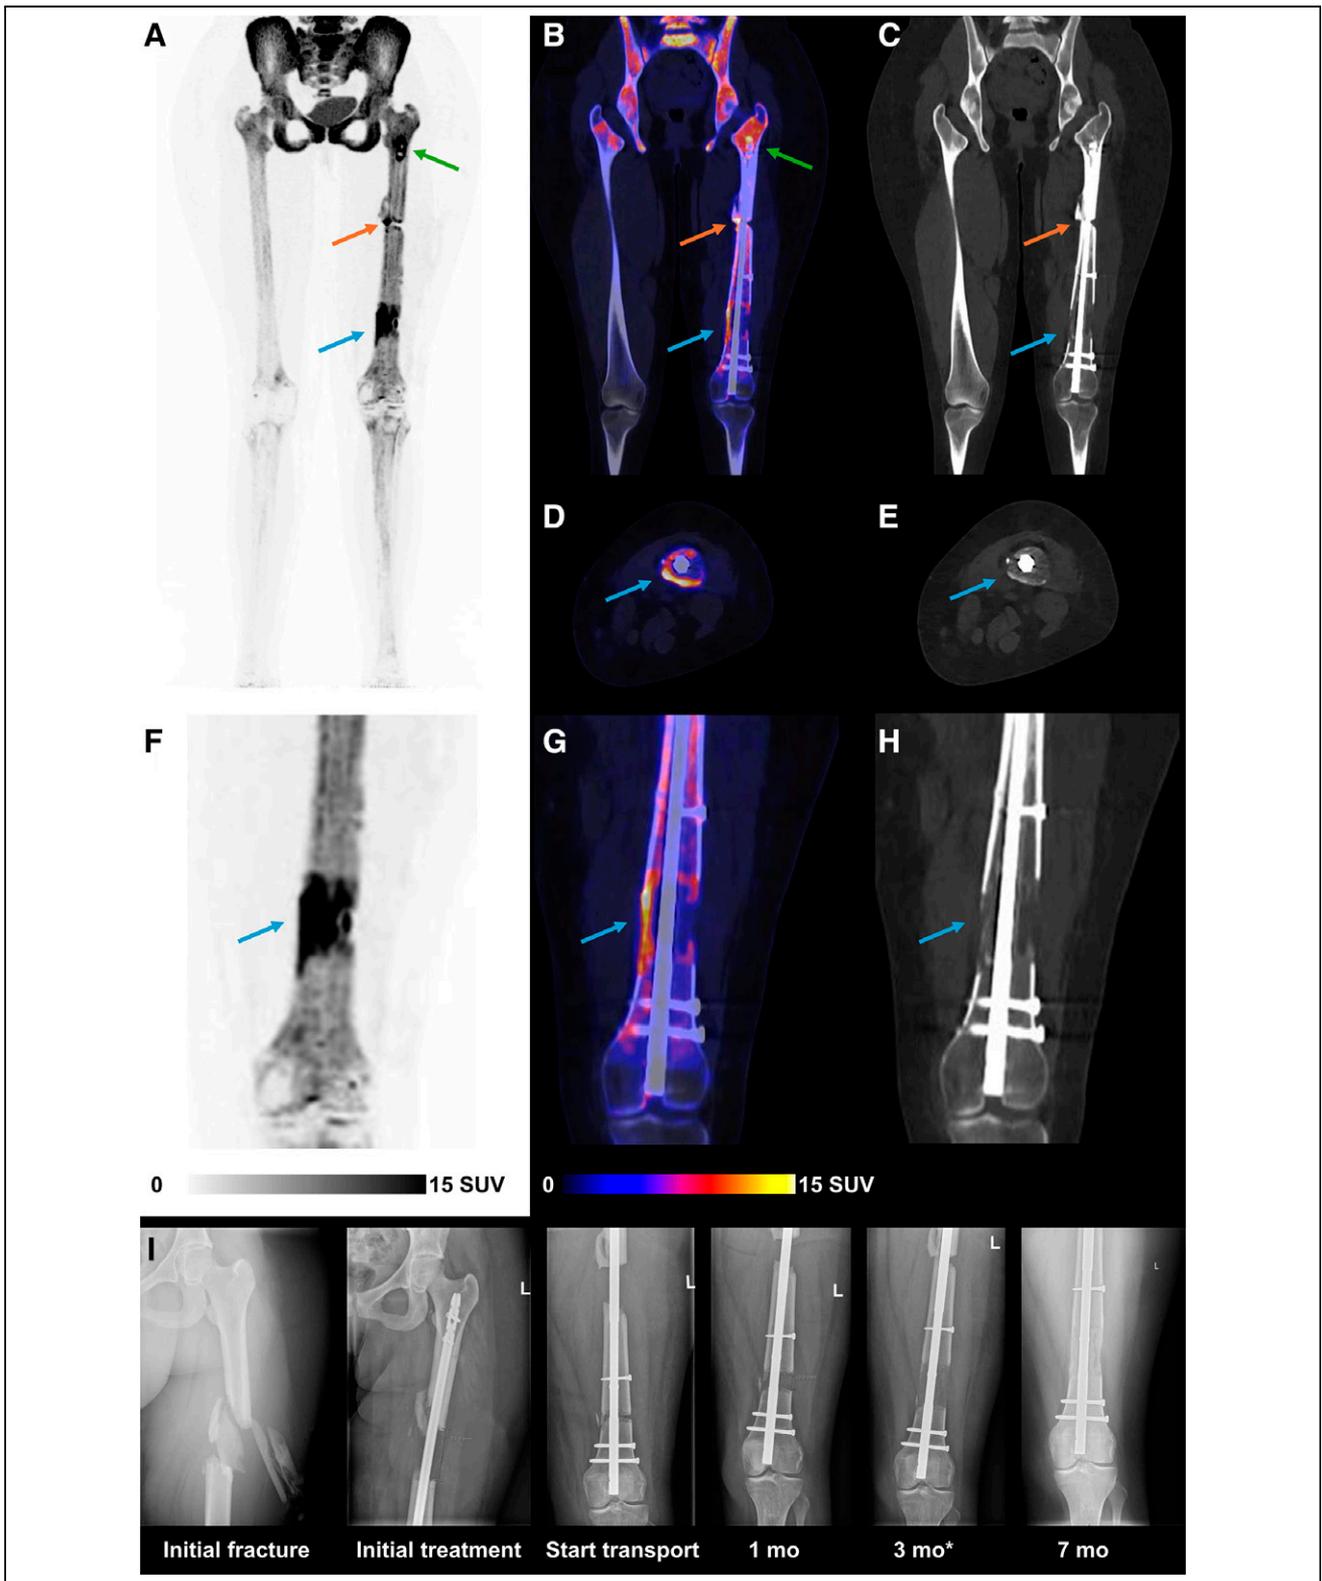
(A) Maximum-intensity projections showing high ^{18}F NaF uptake at bone transport site (blue arrow, SUV_{max} of 35), docking site (orange arrow, SUV_{max} of 27), and proximal screws (green arrow, SUV_{max} of 28), with normal uptake in axial skeleton and bladder. (B and C) Coronal PET/CT image and low-dose CT image of femur, respectively, showing more medial uptake in transport and docking site and with early callus formation, likely due to medial compression (load-bearing area). (D and E) Axial PET/CT image and low-dose CT image, respectively, showing distal transport site with increased anterior, posterior, and medial ^{18}F NaF uptake and early callus formation. (F, G, and H) Close-up of bone transport site, comparing ^{18}F NaF PET, PET/CT, and CT imaging. (I) Monitoring of fracture healing through x-rays: initial fracture and treatment with retrograde femur nail (74-mm bone defect), at start of transport with magnetic intramedullary nail, 1 mo after transport onset (19-mm movement), 3 mo after transport onset, which is 3 d before ^{18}F NaF PET/CT (50-mm movement), and 7 mo after transport onset, showing fracture healing progression.
